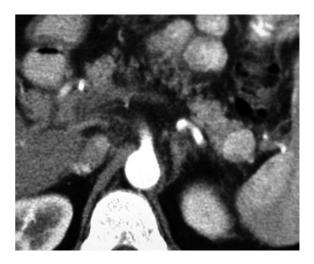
IPAS, pancreatic tail. Distinguishing a lesion such as this hypervascular mass in the pancreatic tail from PNET or metastasis is difficult. Location and enhancement mimicking spleen are suggestive. We have found MRI helpful in these cases
